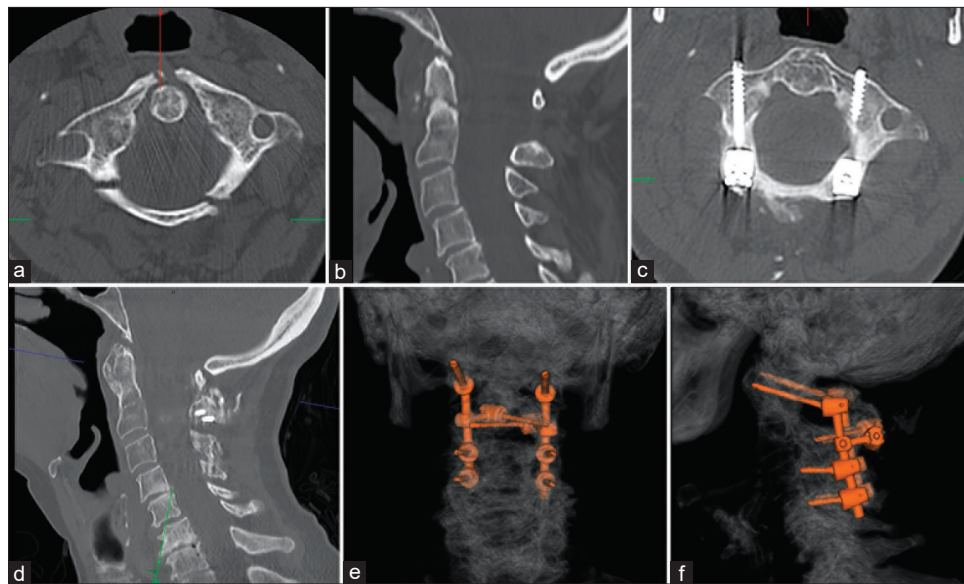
The patient is a 67-year-old woman who presented after a head trauma. Computed tomography demonstrated a type 3 atlas fracture (a) and a type II dens fracture (b). She underwent surgical fixation with C1 lateral mass screws (c), C2 translaminar screws (e, f), and C3 and C4 lateral mass screws (e, f). Follow-up imaging showed bony bridging of the C1 anterior and posterior arches (c), as well as reconstitution of the odontoid peg (d)
